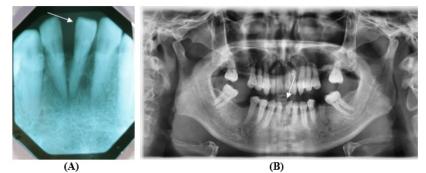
(A) Periapical and (B) panoramic radiographs showed migration of teeth 31 and 42 (white arrow) without the involvement of the alveolar bone
